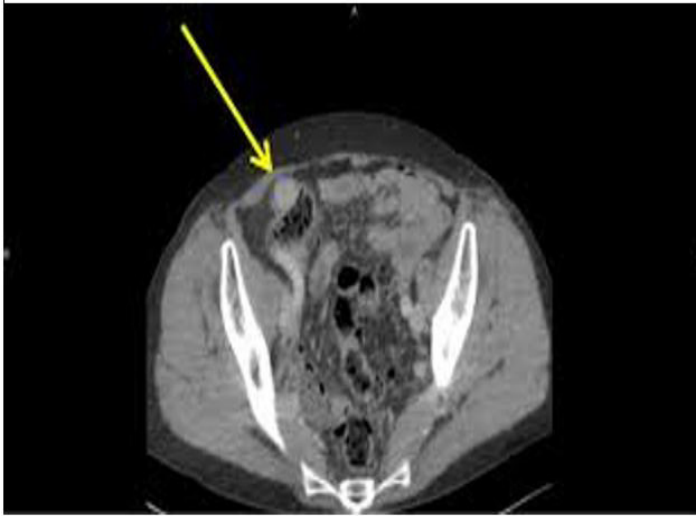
CT scan showing presence of colon schwannoma.
